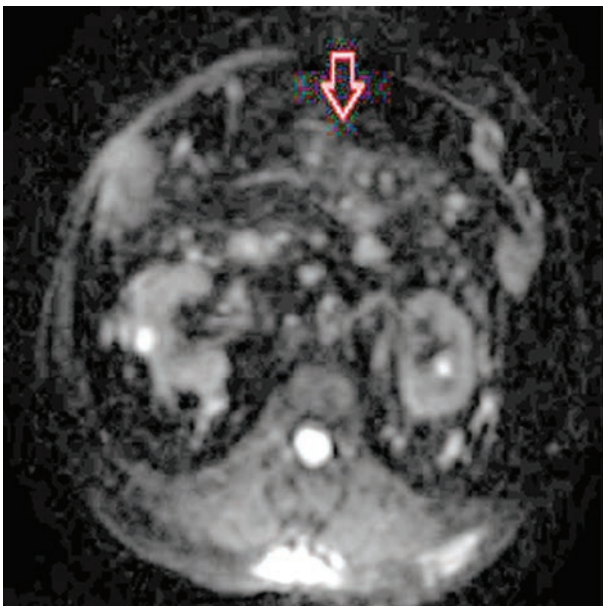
The mesenteric panniculitis does not show a restriction of diffusion on DWI image (red arrow)
